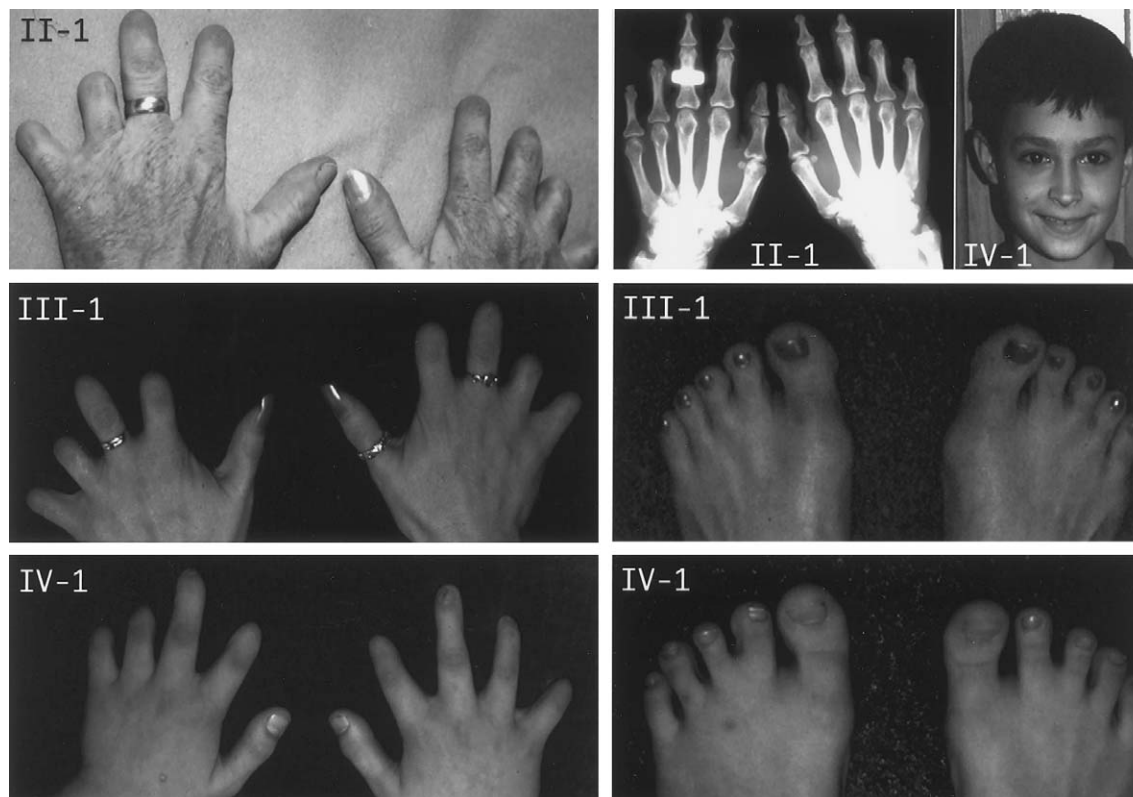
Finger, toe, hand x-ray, and facial features in members of family 2. Identifiers are the same as in fig. 1. Note normal-appearing metacarpals and proximal phalanges—but rudimentary middle/distal phalanges—in the hand radiograph of individual II-1. Digits 2 and 3 on the left hand appear to have a distal phalanx articulating with a proximal phalanx. However, this may be a misshapen middle phalanx, rather than a true distal phalanx. Note that affected individual IV-1 has normal facial features.
